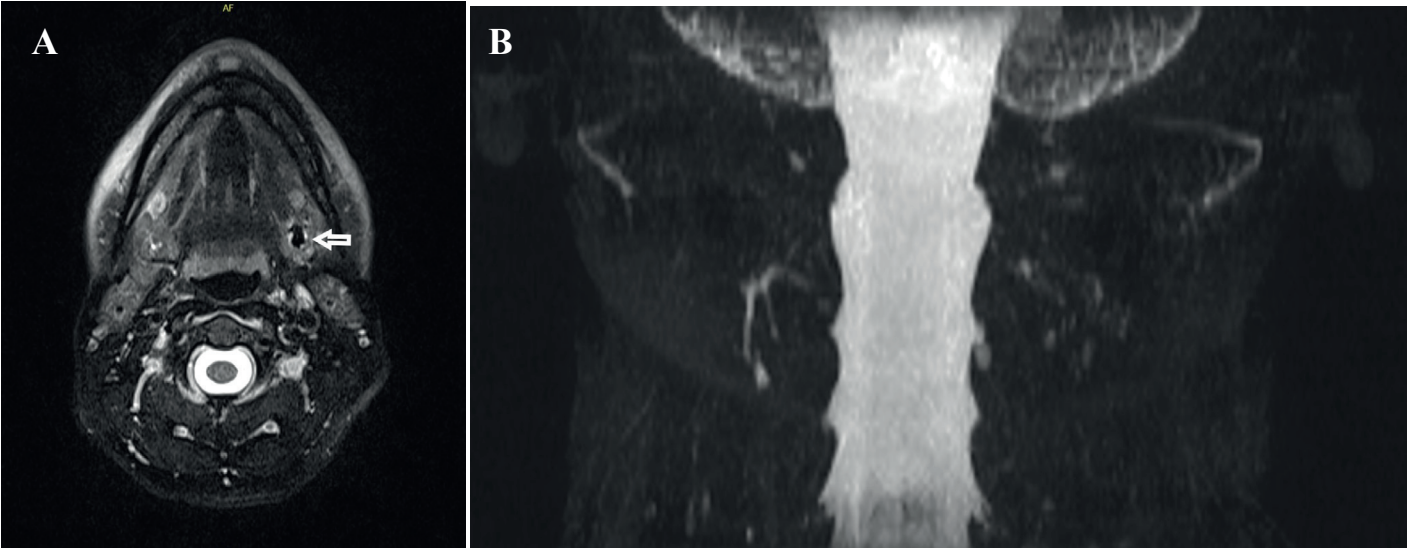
A. Axial T2 image showing a stone before the hilum of the left submandibular gland; B. 3D MRI sialography showing no dilation of the intraparenchymal branches of the ducts
